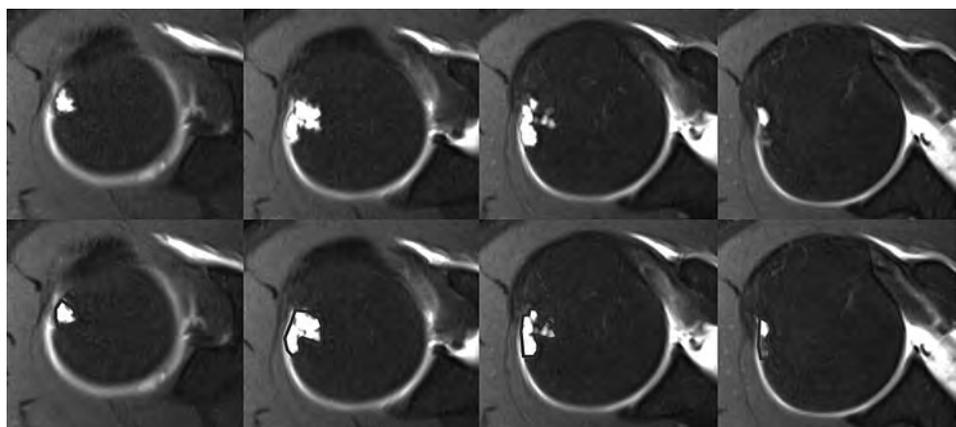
Demonstration of the additive cross-sectional method. The contour defect of the Hill-Sachs lesion (top of panel) has been traced with the polygonal area measurement tool on this fat saturated T1-weighted image (bottom of panel). The process is repeated on all images demonstrating the contour defect.
